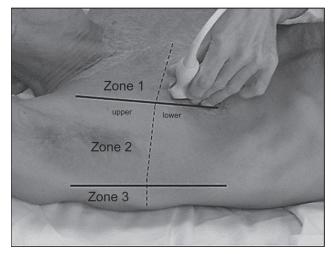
Zones of lung ultrasound imaging. From Reference 18, with permission.
